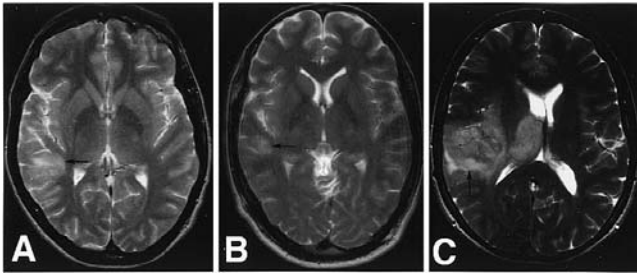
Axial T₂-weighted MR images obtained in each of our three cases at the level of the Heschl gyrus. In all patients, the tumor was located in the right cerebral hemisphere (arrows). A: Case 1, with a 2 × 3-cm area of abnormal T₂ signal within the Heschl gyrus. B: Case 2, with an 8-mm area of abnormal T₂ signal within the gyrus. C: Case 3, with a T₂ signal abnormality centered on the Heschl gyrus and the planum temporale, with extension into the long gyri of the insula and ipsilateral thalamus. None of the tumors enhanced on T₁-weighted imaging after Gd injection (not shown).
